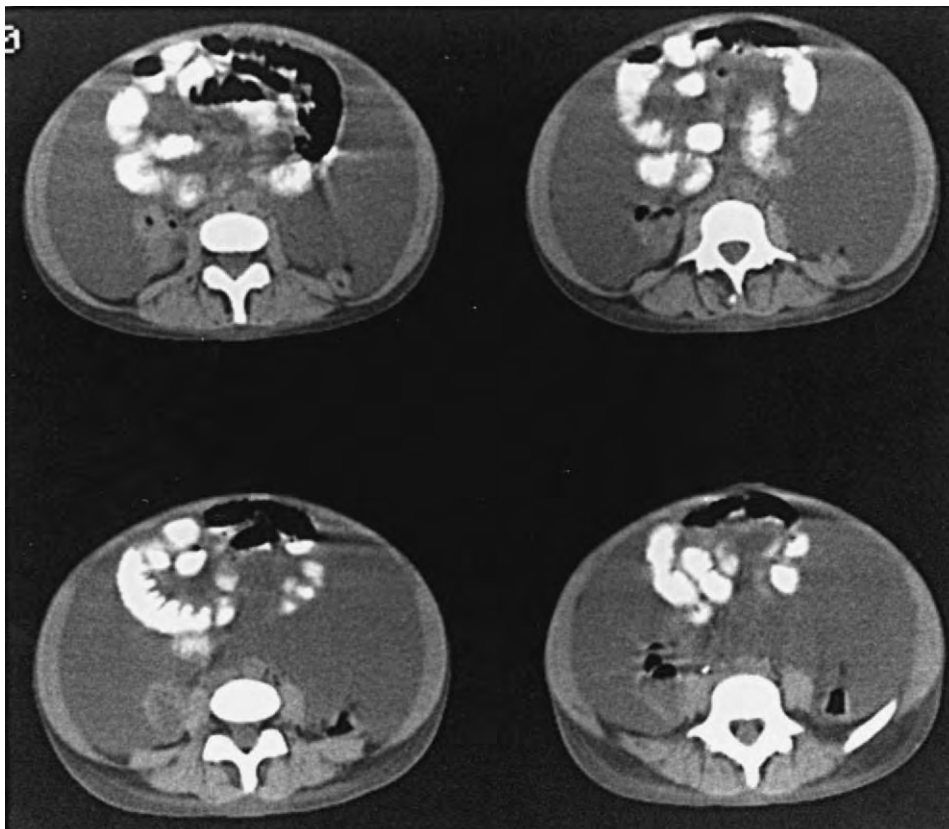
Four computed tomography scans showing extensive pancreatic ascites in a young female patient with alcoholism. The small bowel loops float centrally, and ascitic fluid fills the abdomen.
